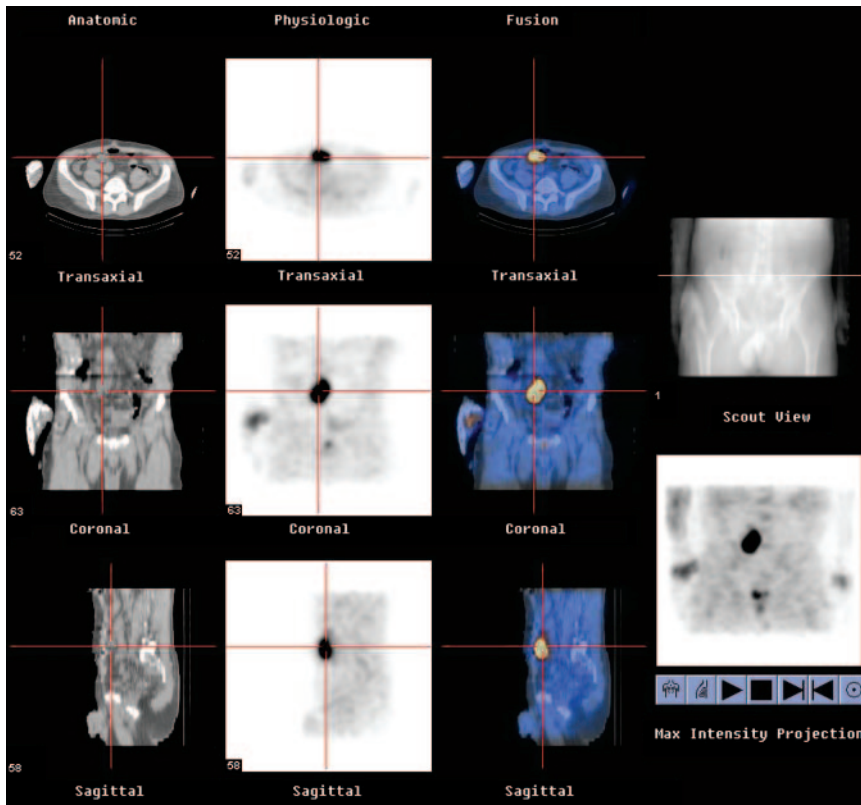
A 57-y-old patient with known colorectal cancer was referred for ^{18}F -FDG study because of rising carcinoembryonic antigen levels. Coincidence images detected increased uptake in anterior abdomen. Fusion of coincidence data with low-resolution CT image localized uptake in dilated collecting system of right ectopic kidney. Patient was disease free on clinical follow-up.
